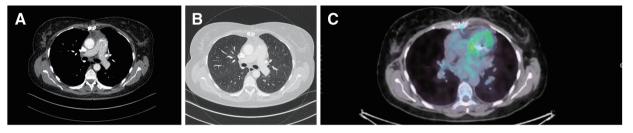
(A) and (B) Two months after surgery, the thoracic CT scanner showed no distant metastasis. (C) Two months after surgery, PET/CT confirmed the local invasion of the right ventricle. PET/CT: positron emission tomography/computed tomography
